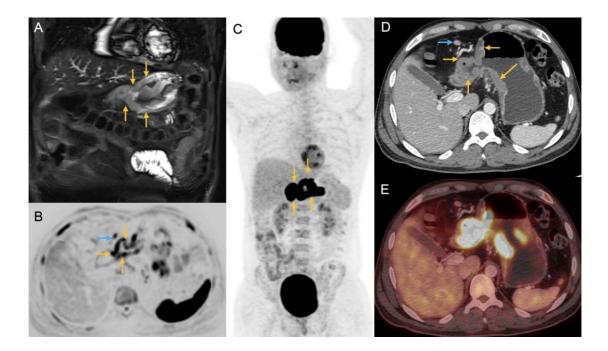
(A) Coronal STIR, (B) DWI, (C) PET MIP, (D) Axial CECT and PET-CT images showing lymphomatous involvement of the distal body and pylorus of the stomach in a case of DLBCL.
